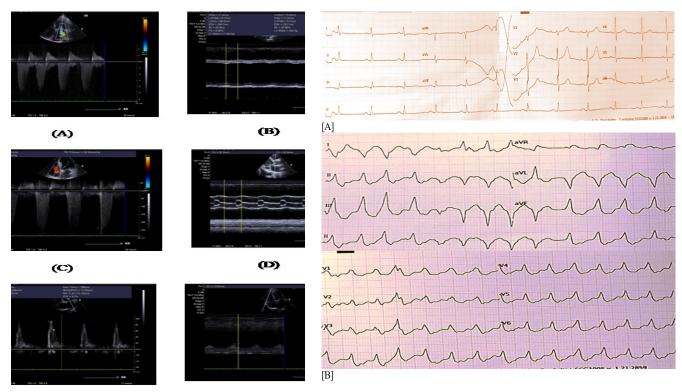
Echocardiographic images from patient study [A] CWD across MV, [B] M-mode measurement of LV EF%, [C] CWD across TV , [D] M-mode across aorta and LA, [E] PWD across MV, [F] TAPSE.
